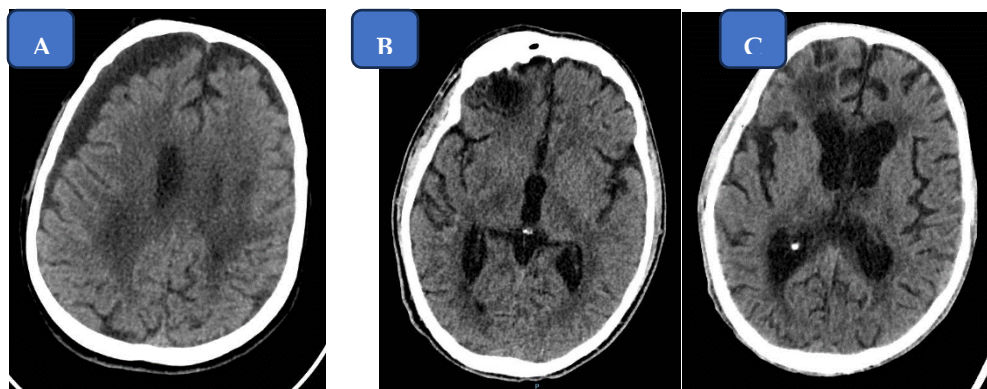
Successive cerebral CT scans (A 09.08.2023 frontoparietal hygroma; B 20.11.2023 frontal hypodensity, post-concussive sequelae; C 12.06.2024). Frontoparietal hypoattenuating areas. The ventricular system displays slightly increased dimensions, with an Evans index of approximately 0.35, implying borderline ventricular enlargement; additionally, fine periventricular hypodensities indicate potential trans ependymal edema. Fig B and C: the mid-line structures showed no signs of deviation. Furthermore, there was a complete resolution of the right-sided subdural fluid accumulation.
